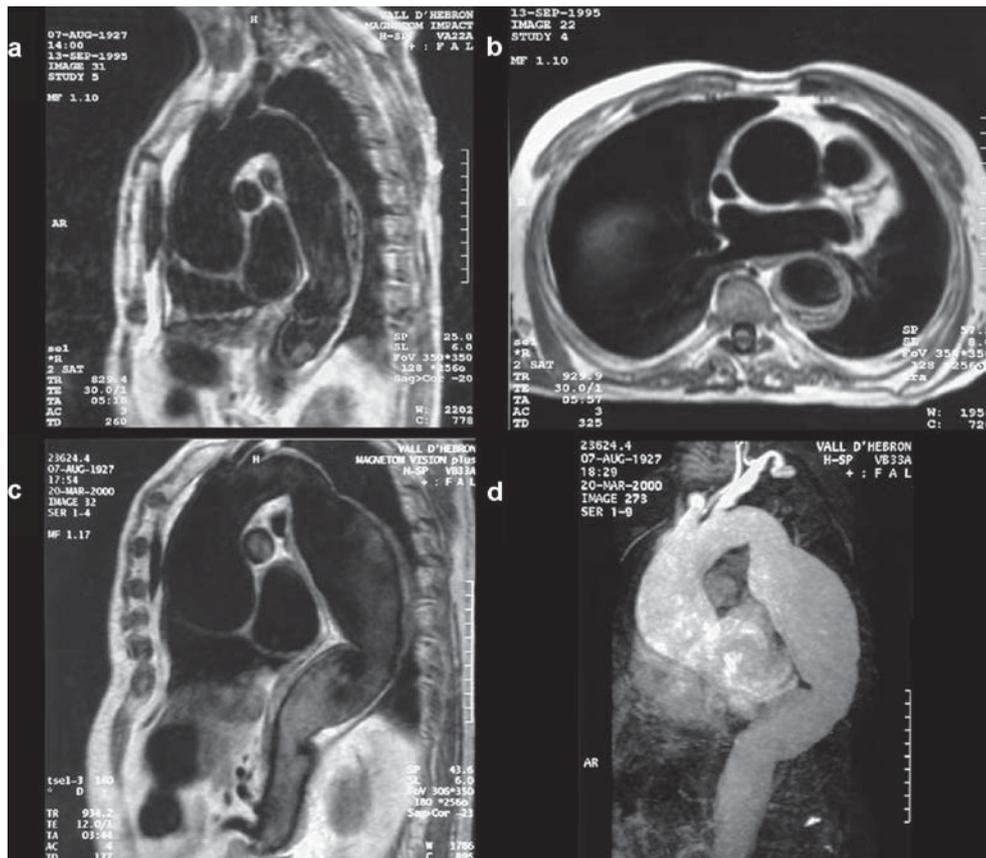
Intra-mural haematoma in descending aorta in acute phase in sagittal (a) and axial (b) views. After a 5-year follow-up, a fusiform aneurysm was diagnosed by spin-echo black-blood (c) and gradient-echo MRI (d) sequences
